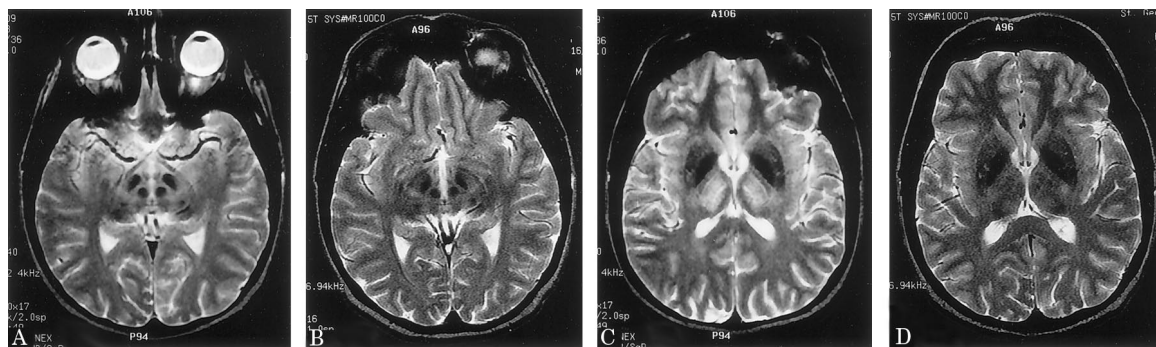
weighted MR images. The initial scans at the level of the midbrain (A) and thalamus (C) are shown; (B) and (D) show corresponding images 1 year later.
